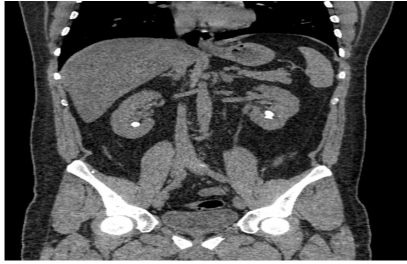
Bilateral kidney stones (Father's computed tomography image)
